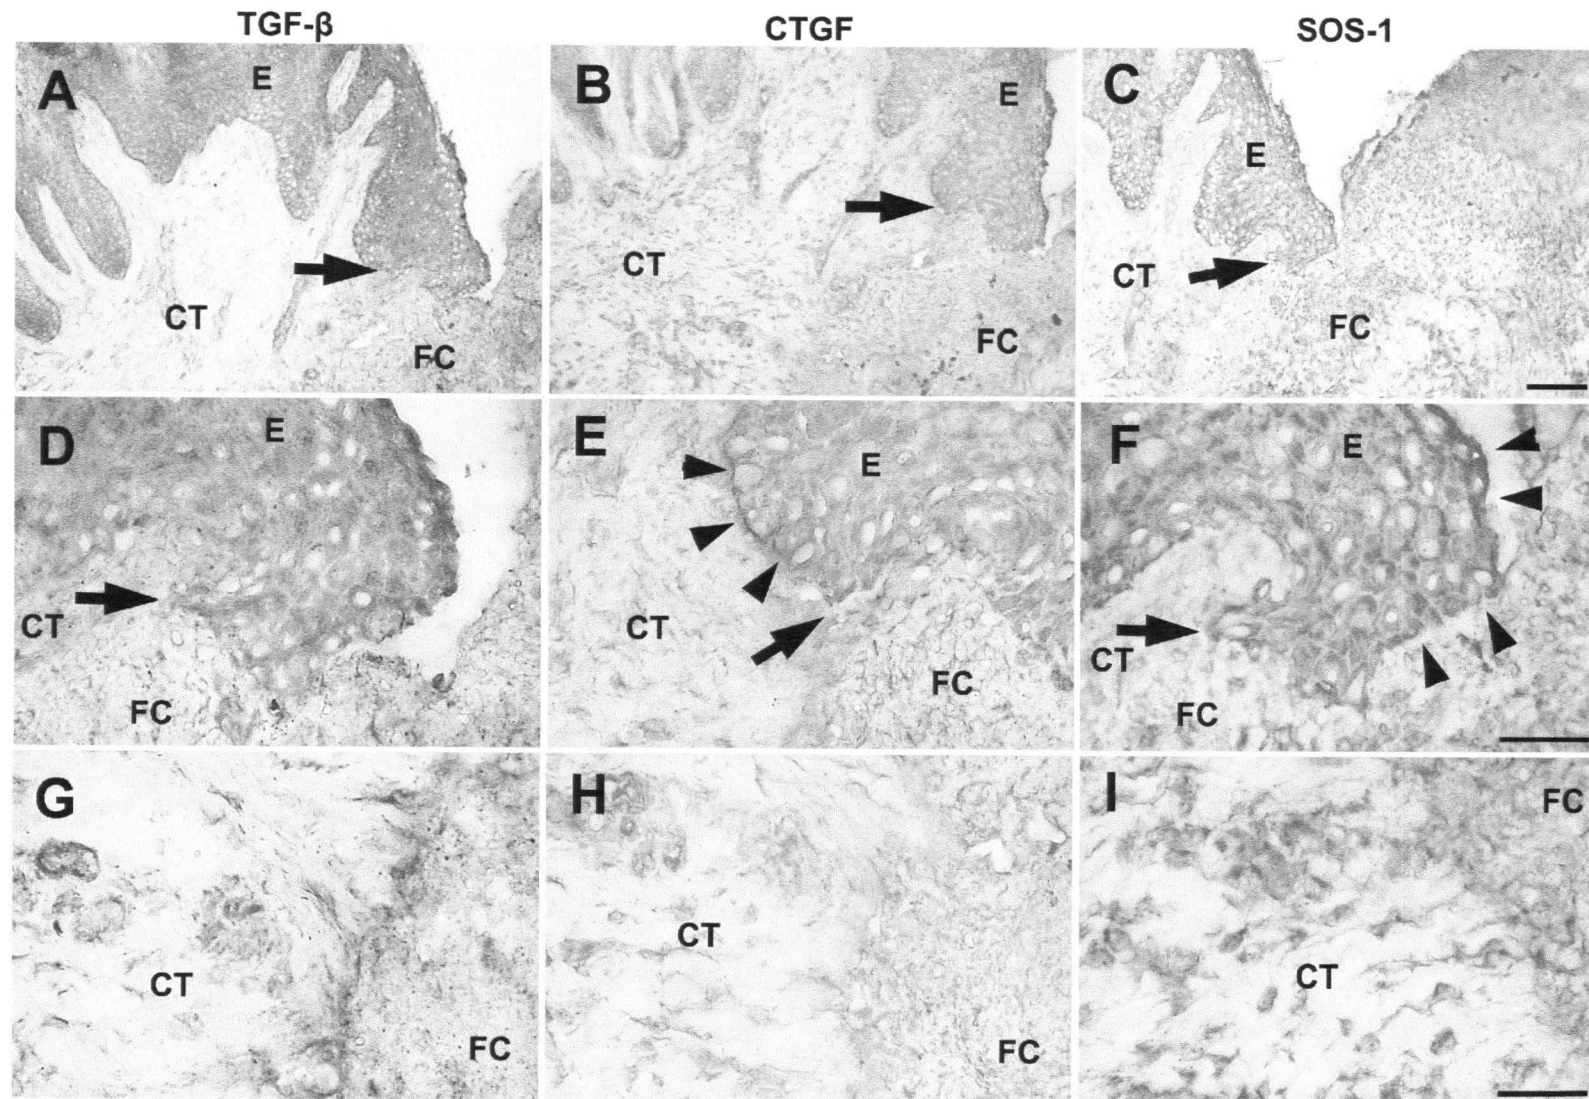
Expression pattern of TGF- β (A, D and G), CTGF (B, E and H) and SOS-1 (C, F and I) in palatal attached gingiva 3 days after wounding. A-F: Arrows indicate the wound edge. E and F: Arrowheads indicate localization of strong immunoreactivity at the epithelial cells. E = epithelium; CT = connective tissue; FC = fibrin clot. Bar 100 μ m
